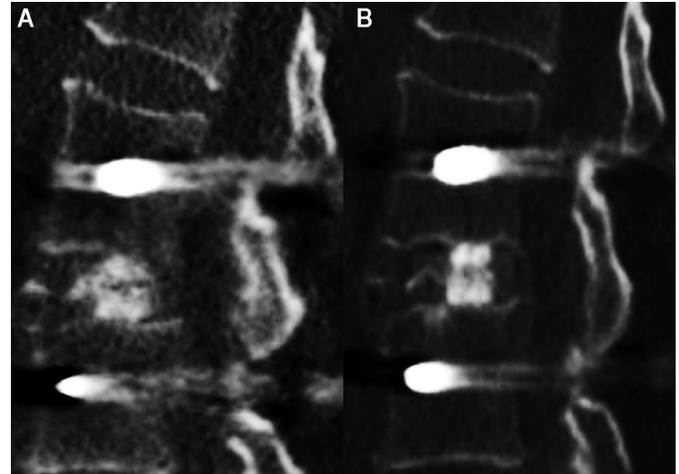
Example of extreme lateral interbody fusion. (A) Sagittal computed tomographic (CT) scan of a 52-year-old woman, immediate postoperation. (B) Sagittal CT scan of the same patient, 2 years after the procedure.
